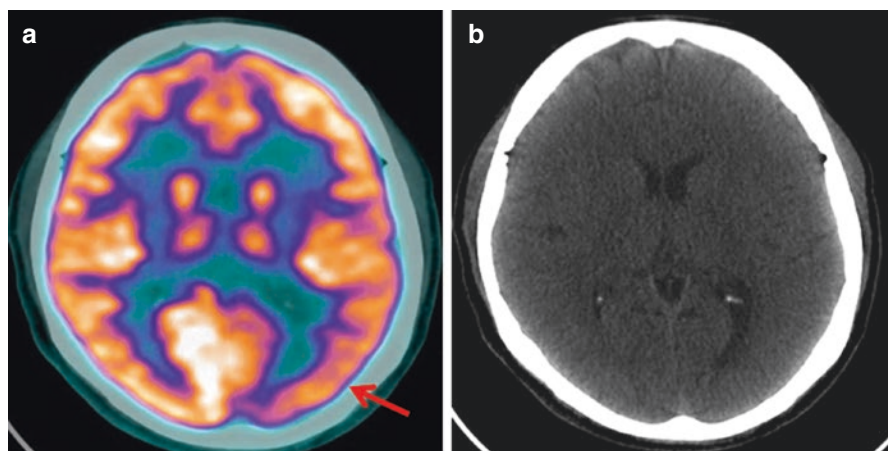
(a–d) A 31-year-old patient with left hemisphere epilepsy. Axial fused ^{18}F FDG PET/CT (a), axial CT (b), fused ^{18}F FDG PET/MR (c) and T2 FLAIR (d) at the level of the thalami show area of hypometabolism in the left occipitotemporal region (a, c arrows) with corresponding high signal intensity in the periventricular region of the posterior horn of the left lateral ventricle (d, arrow) raising the suspicion of previous encephalitis.
